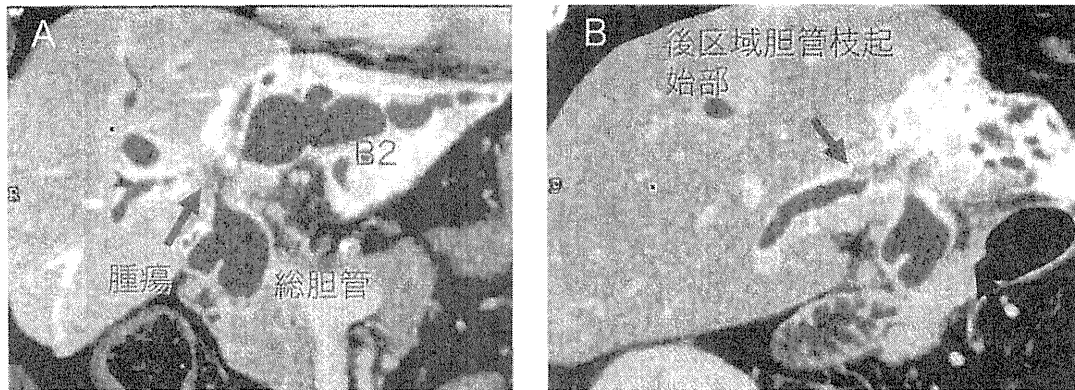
肝門部胆管癌症例のMD-CT (MPR 冠状断像)
